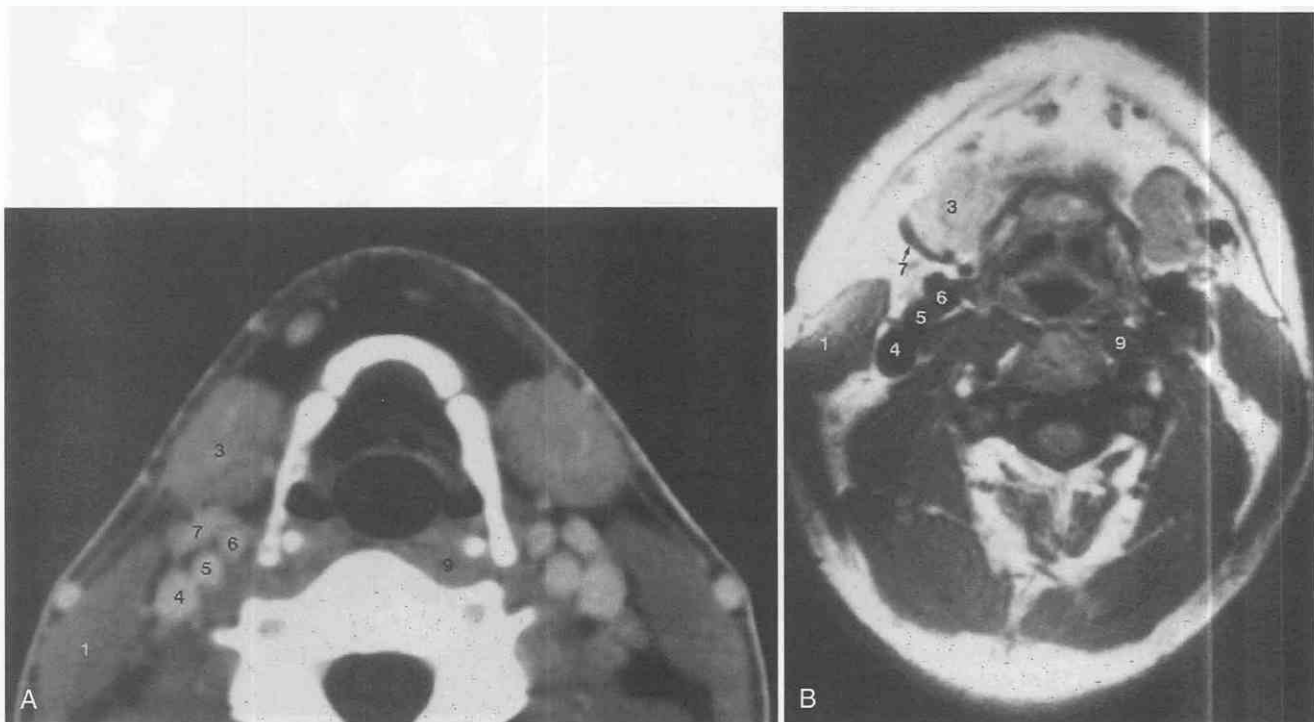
Normal axial anatomy at the level of the hyoid bone. A, Contrast-enhanced CT scan. Note that the normal retrofacial vein or proximal external carotid artery might be mistaken for a lymph node or other mass on a noncontrast examination. B, T1-weighted MR image demonstrates the same soft tissue and vascular anatomy without intravenous contrast. 1, Sternocleidomastoid muscle; 3, submandibular gland; 4, internal jugular vein; 5, internal carotid artery; 6, external carotid artery; 7, retrofacial vein; 9, longus colli muscle.
